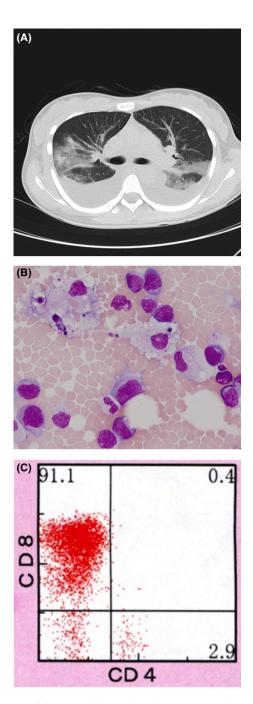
Radiological and hematological picture on admission. (A) CT scan showing bilateral pneumonia with ground-glass opacity and bilateral pleural effusion. (B) Bone marrow aspirate smear documenting medium-sized to large atypical lymphoid cells with irregular nuclei, prominent nucleoli, and basophilic cytoplasm and active histiocytes with prominent hemophagocytosis. (C) Flow cytometric analysis of bone marrow cells indicating a highly predominant population of CD8-positive T cells.
